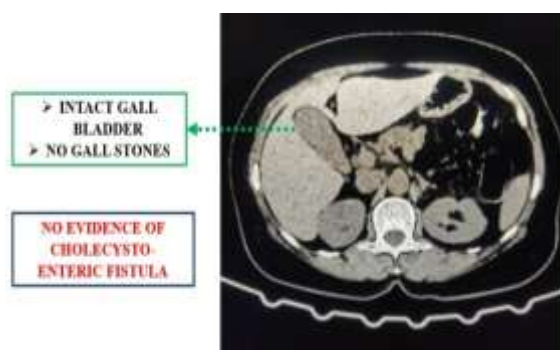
Contrast Enhanced CT Abdomen on the day of admission -Axial section showing an intact gall bladder wall, with no gall stones and no evidence of Cholecysto-enteric fistula
